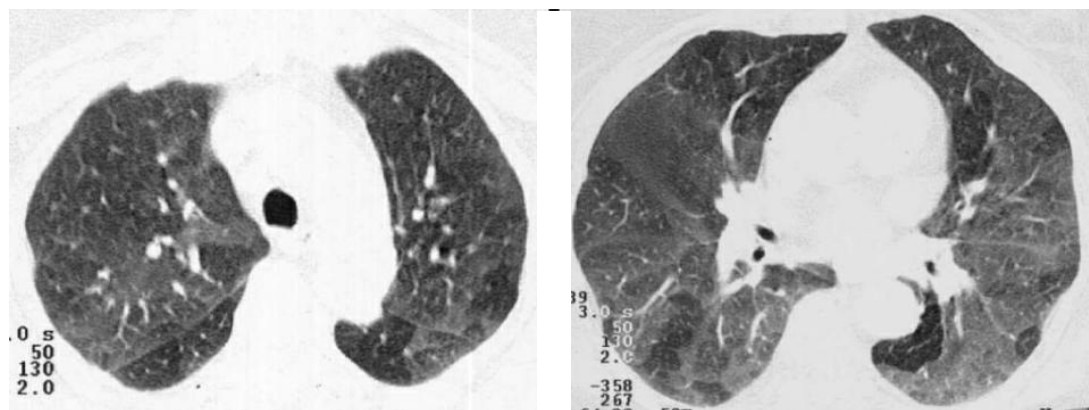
Axial CT scans with lung window settings acquired in the expiratory phase, revealing, in the posterior segments of the lower lobes, different parenchymal densities, with areas of decreased attenuation associated with air trapping due to small airway obstruction.
